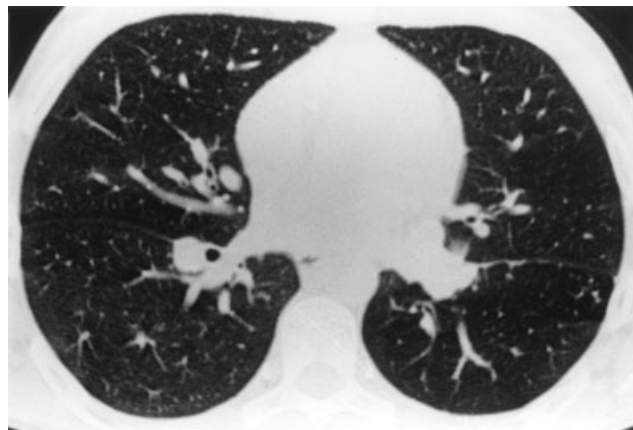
CT scan from case 4 through lower zones shows complete occlusion of left lower bronchus, but no adjacent mass. There is some associated volume loss of left lower lobe, and more caudal sections show extensive bronchiectatic changes, with mucus plugging of dilated bronchi.
